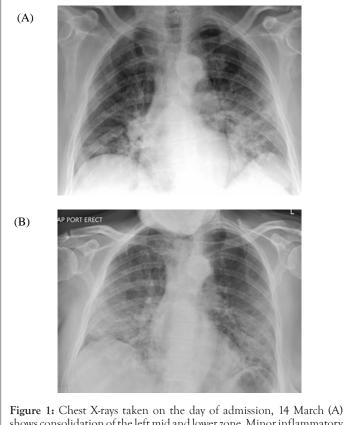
Chest X-rays taken on the day of admission, 14 March (A) shows consolidation of the left mid and lower zone. Minor inflammatory infiltrate right base was also noted. (B) Chest X-ray taken on 24 March shows worsening air space opacity in mid and lower zones bilaterally.
